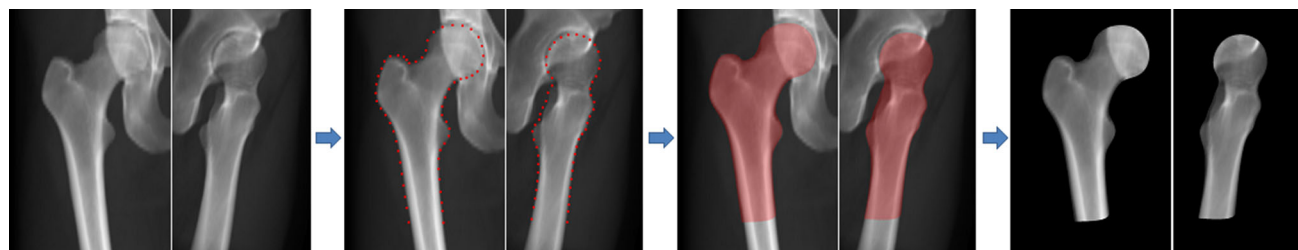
Femoral ROI extraction. Please note that all images are cropped to save space. *Left* a given pair of X-ray images; *middle-left* after automatic contour extraction; *middle right* after binary ROI mask generation; *right* the extract femoral regions
